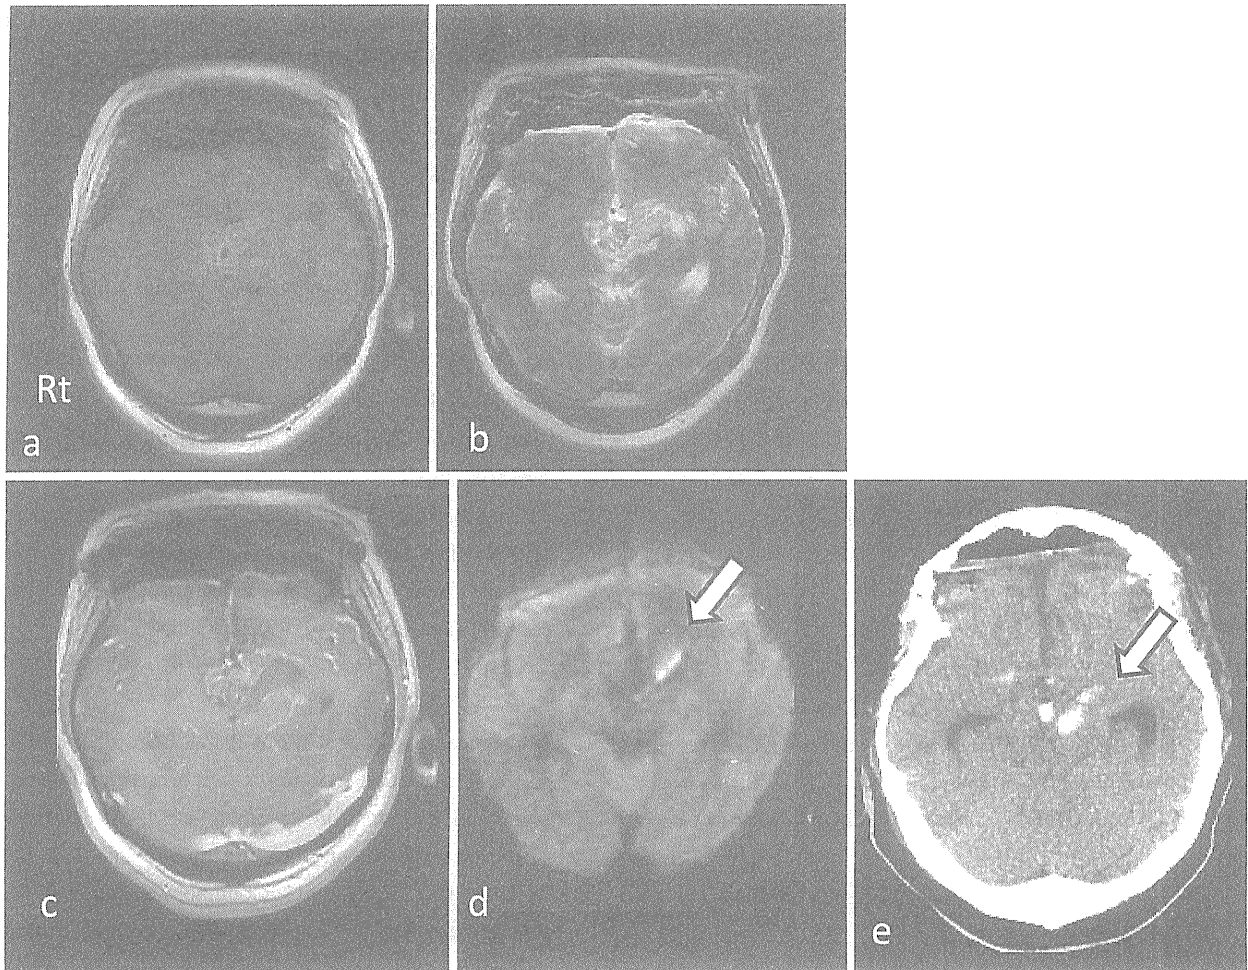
Intraoperative MR images (a: T1-weighted, b: T2-weighted, c: T1 with Gadolinium, d: DWI). Intraoperative DW image shows intra-tumoral hemorrhage (d: open arrow). Post-operative CT shows the intra-tumoral hemorrhage (e: open arrow).
